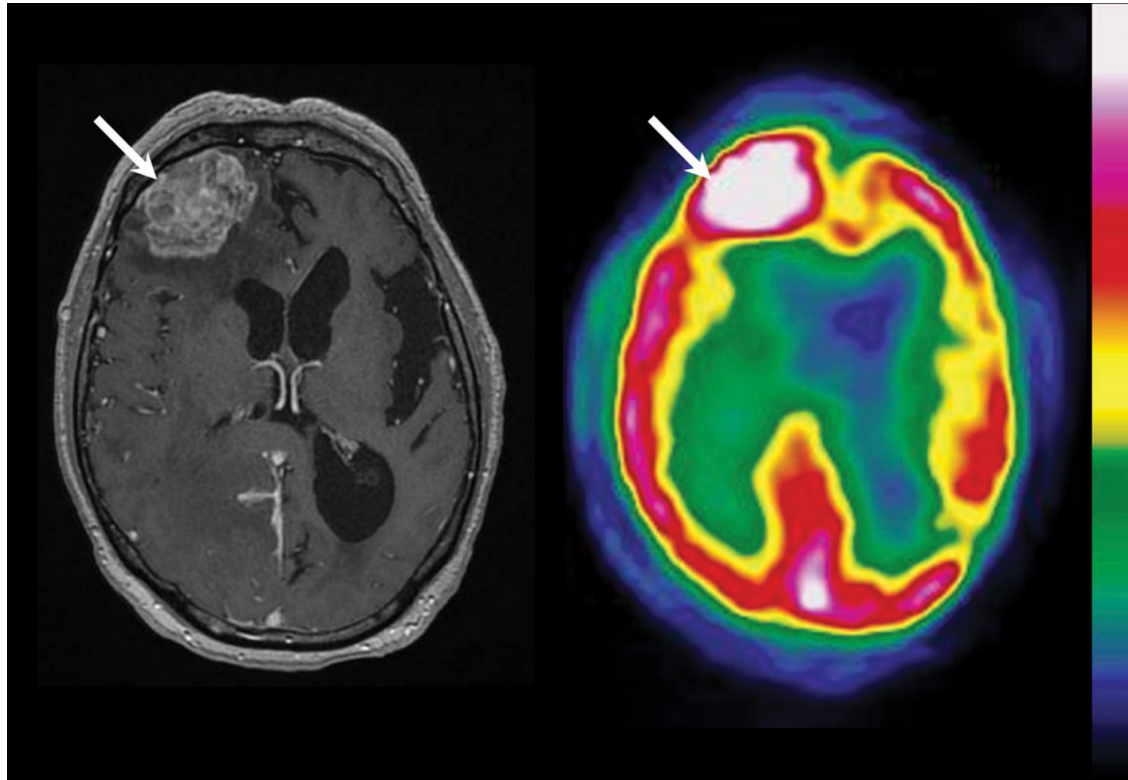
Images of a glioblastoma. On the left hand side - a MRI scan, on the right hand side - a PET scan. (Image taken from [13])
